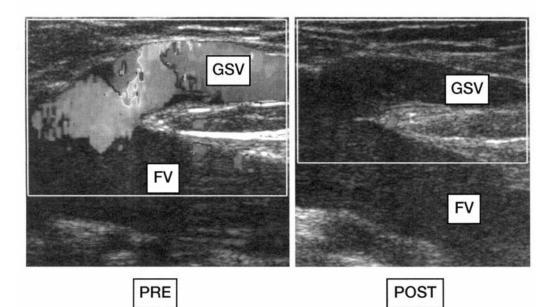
Color duplex ultrasound images showing pre (left) and post (right) radiofrequency treatment. Note the absence of color flow in the great saphenous vein (GSV) in the post treatment image on the right. FV = femoral vein. (Photo courtesy of Olivier Pichot, MD, reproduced with permission).
